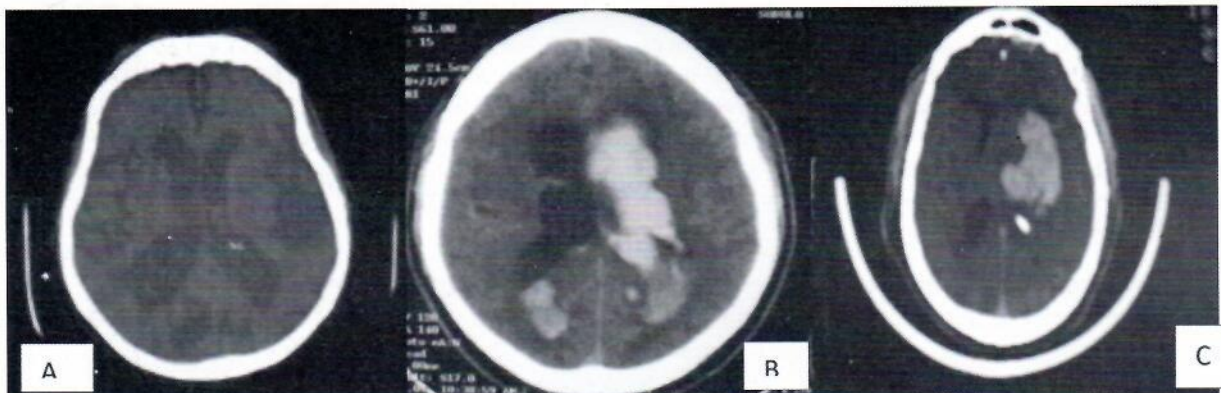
(A) Axial non-enhanced cranial CT scan showing prominence of the cerebral sulci and ventricles in keeping with cerebral atrophy. A triangular shaped hypodensity is seen in the left parietal lobe consistent with a typical watershed cerebral infarct. (B) Axial non-enhanced cranial CT scan showing extensive intraventricular hemorrhage from a large putaminal hemorrhage (C) in a patient with hemorrhagic cerebrovascular accident.
